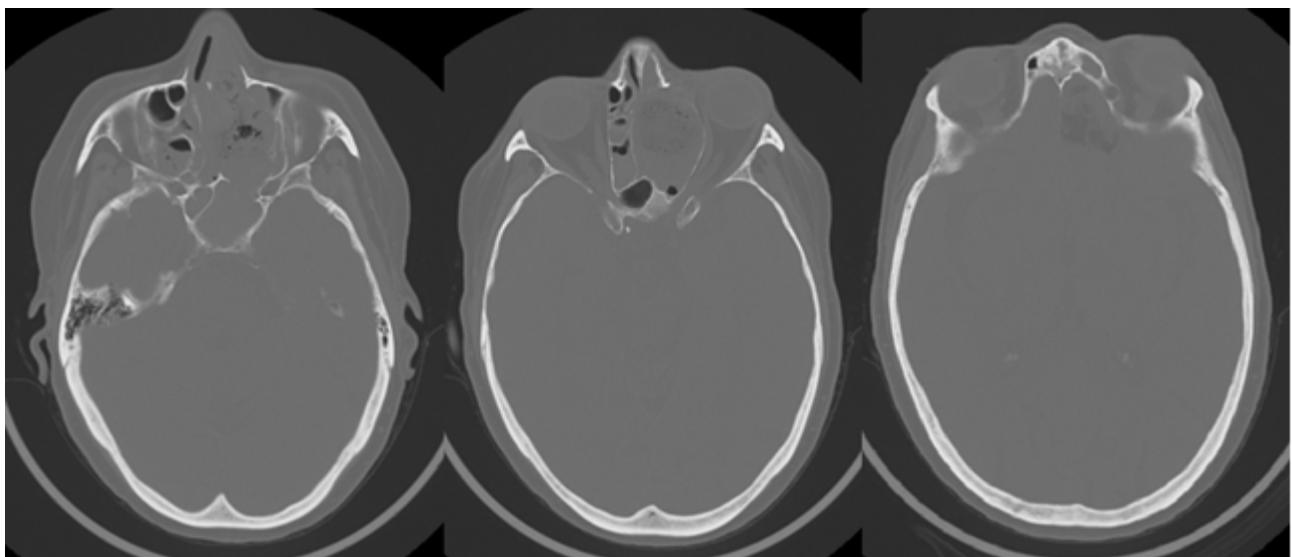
Post-operative CT-scan
